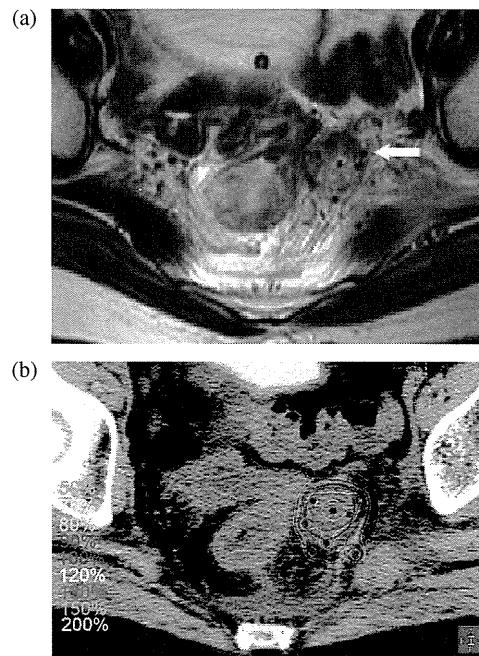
(a) Magnetic resonance image of a patient obtained just after implantation. The flexible applicator is shown as a black dot (arrow). (b) Isodose curves on computed tomography image of the patient in Fig. 2(a). CTV is outlined with a thick red line based on the MRI image. CTV was almost covered by the 100% isodose line (thin red line).
